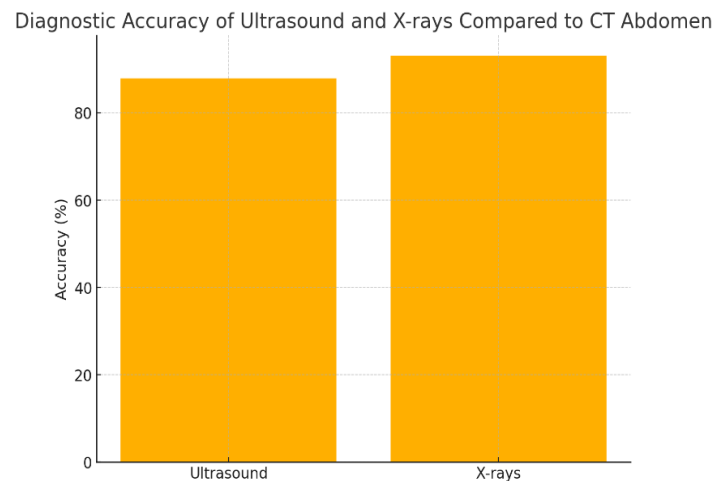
Diagnostic Accuracy of Ultrasound and X-rays Compared to CT Abdomen
